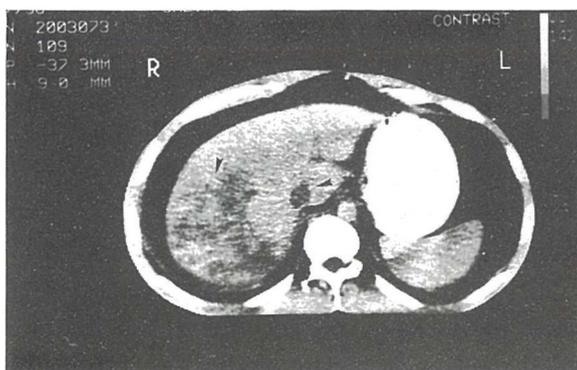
a) CT shows multiple hypodense lesions in the right lobe of the liver in a patient with BD, b) control CT demonstrates no visible lesions and left lobe liver cyst (arrow) in the same patients
